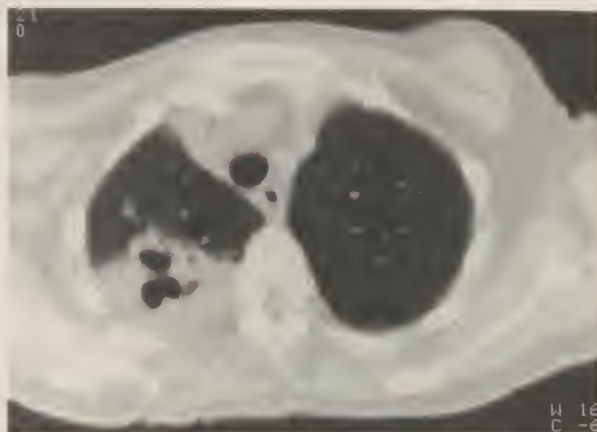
CT scan showed the infiltrate to be cavitary.
